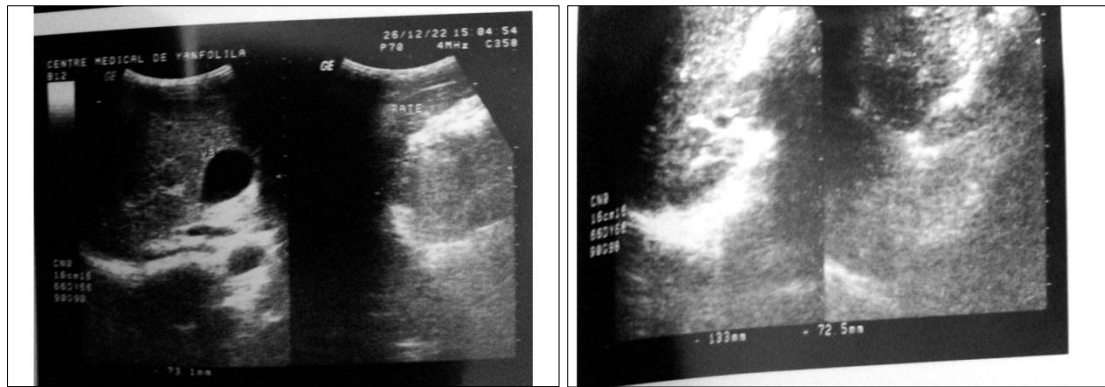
Abdominopelvic Ultrasound.
